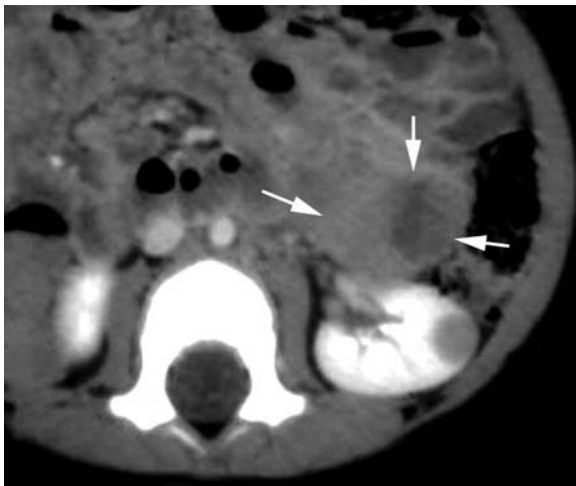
Metastatic neuroblastoma in an 18-month-old boy presenting with leg pain. Axial contrast-enhanced CT scan shows an enhancing (83 HU) 1 cm solid lesion in the left kidney. A metastasis was present in the femur. The lower margin of an adrenal mass extends anterior to the kidney (*arrows*). Lesions were biopsy proven. (With permission from CURRY 1995)
